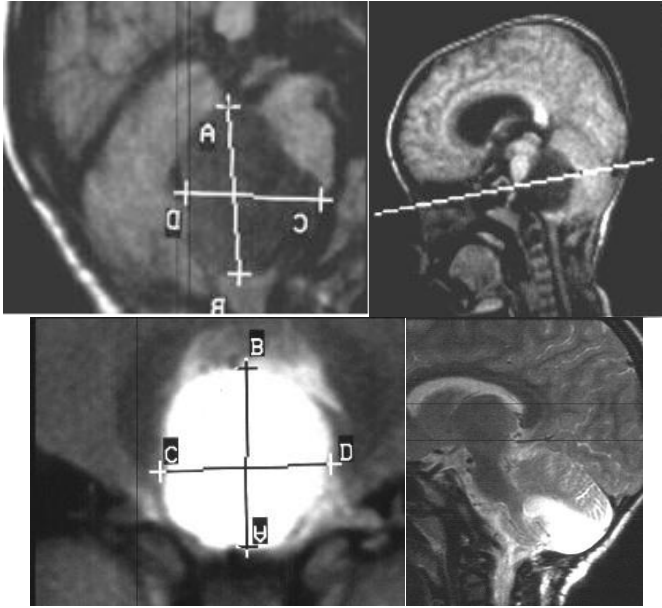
Posterior fossa dermoid cyst. MRI T1 and T2 sequences.
